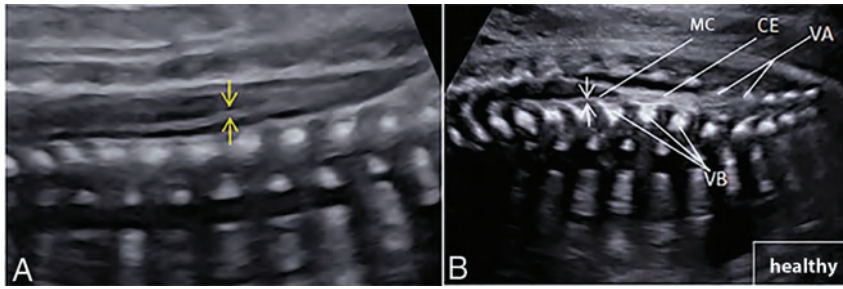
The midsagittal view of the spine on a sonogram in SAH and healthy fetuses. *A*, There are uniform thickening and a strong echo in the subarachnoid space between the pia mater spinalis and the arachnoid membranes of fetal SAH (yellow arrows). *B*, The normal fetal pia mater and arachnoid membrane are relatively close, forming a narrow space (white arrows). MC indicates medullary cone; CE, cauda equina; VA, vertebral arch; VB, vertebral body.
